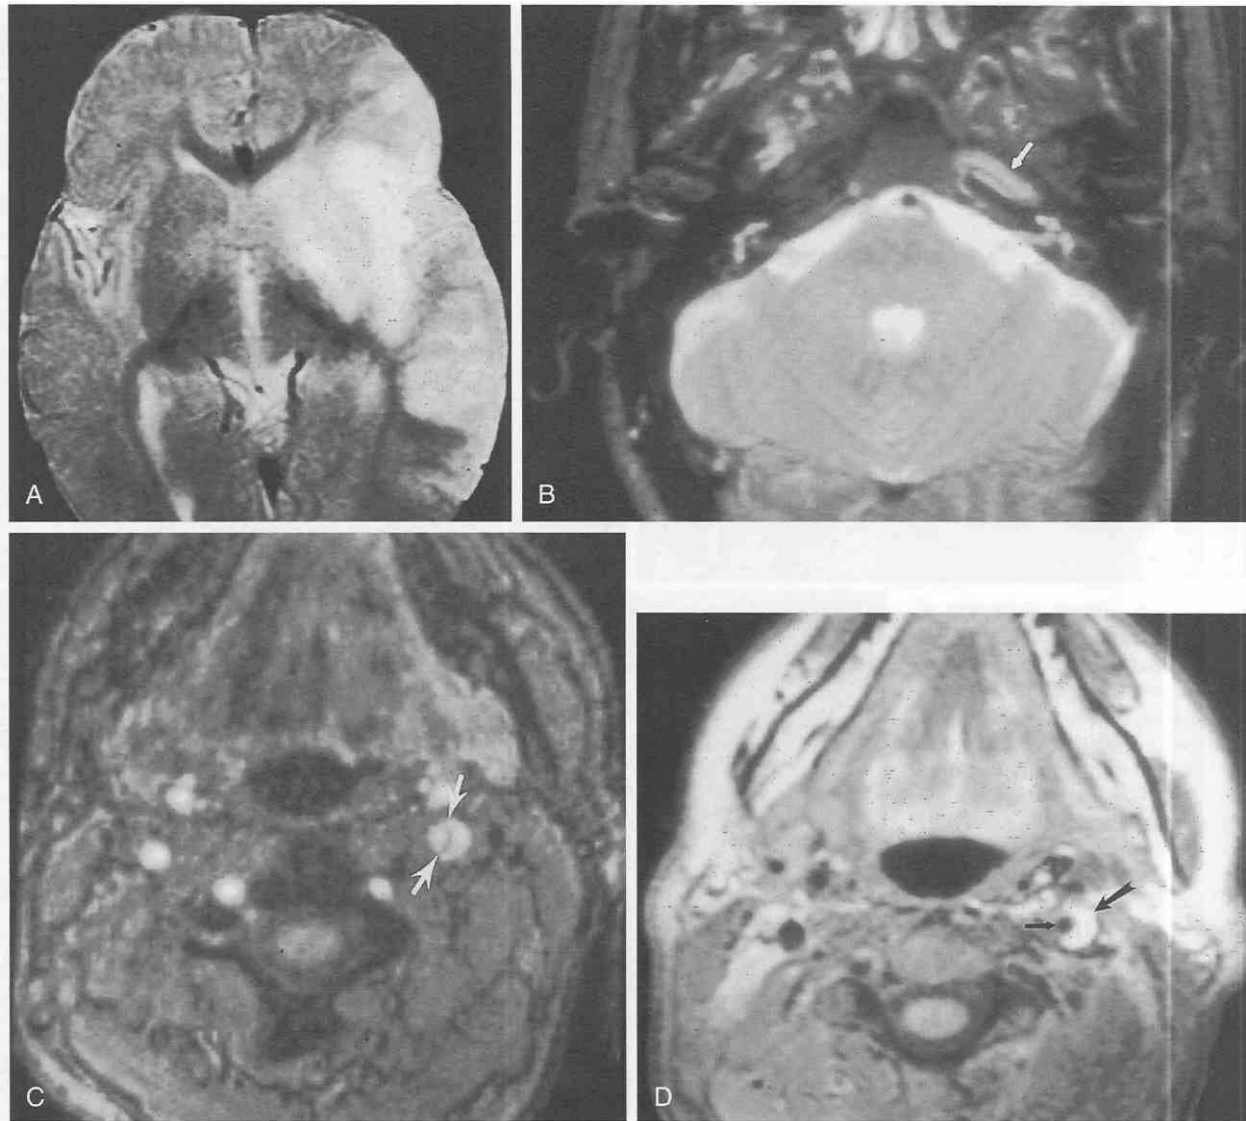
Acute left internal carotid artery dissection. *A*, Axial T2-weighted image shows extensive infarction in the territory of the left middle cerebral artery. *B*, Axial T2-weighted image through the left of the temporal bone shows abnormal increased signal within the petrous segment of the internal carotid artery (*small arrow*). *C*, Axial "source" image from 3D time-of-flight MRA shows the presence of a low-signal intimal flap (*arrows*) within the upper cervical internal carotid artery. *D*, Unenhanced axial T1-weighted image through the same level reveals a crescentic area of high signal representing thrombus (*arrows*). A small focus of flow-related signal void represents the remaining portion of the lumen.
